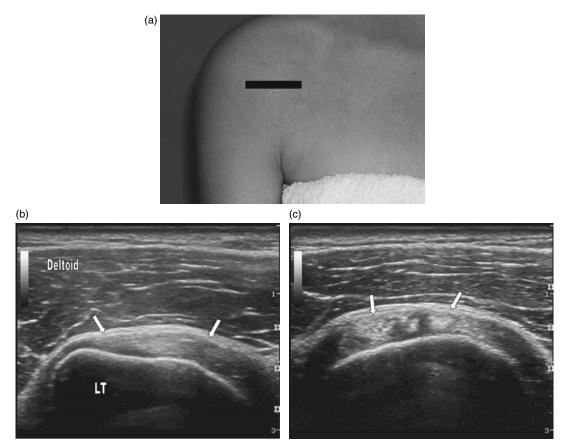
Subscapularis tendon (arrows). (a) Transducer position and corresponding (b) longitudinal ultrasound image. (c) Subscapularis in the transverse plane demonstrating the normal appearance of the multipennate hyperechoic tendons. LT, lesser tuberosity.
